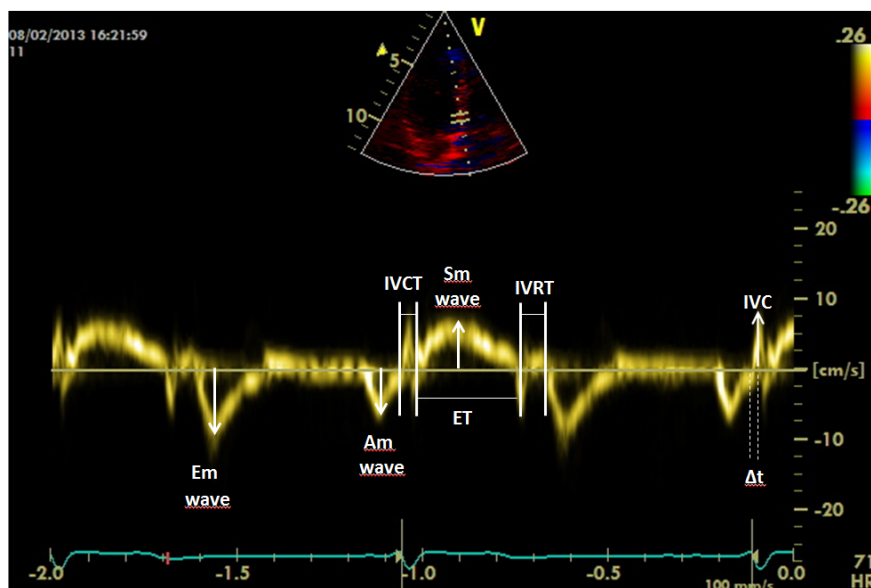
Tissue Doppler Imaging Measurement
